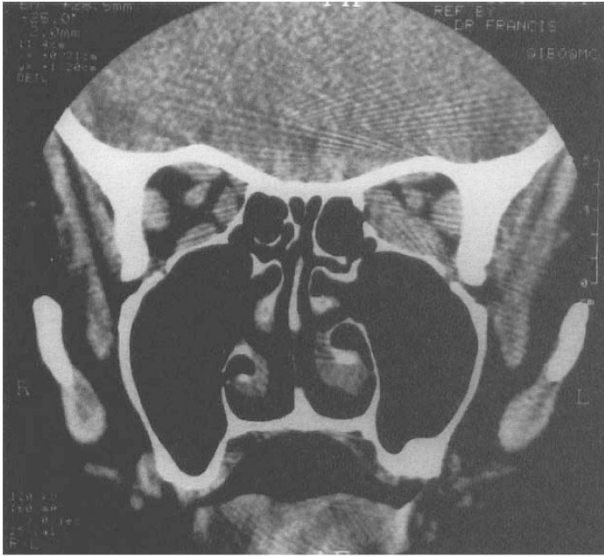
Coronal CT scan showing crowded muscles at the left orbital apex.
